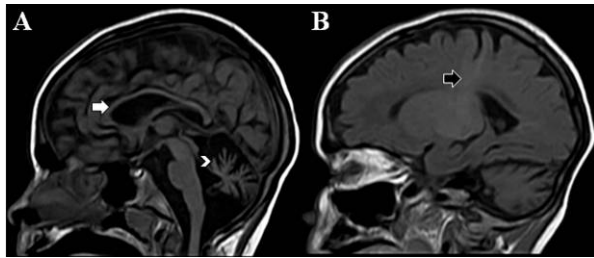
CNS MRI in P1, T1-weight sequence. Atrophy of the corpus callosum (A; white arrow) and of the cerebellum (A; white arrowhead) is demonstrated, together with preserved myelinisation of the corticospinal tract and its proximity upstream of the internal capsule (B; black arrow). Similar findings have been found in P2, the sister of P1
